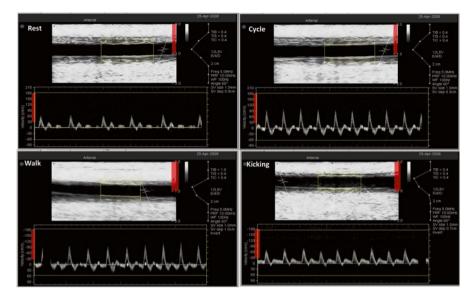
Blood flow patterns during exercise. Echo-Doppler images from the brachial artery diameter and blood flow pattern under resting conditions (a), leg cycling exercise (b), walking exercise (c), and leg kicking exercise (d). Note the marked differences in blood flow patterns between the four different conditions
